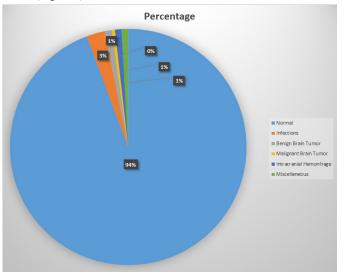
A Chart showing CT scan findings in patients with headaches.
